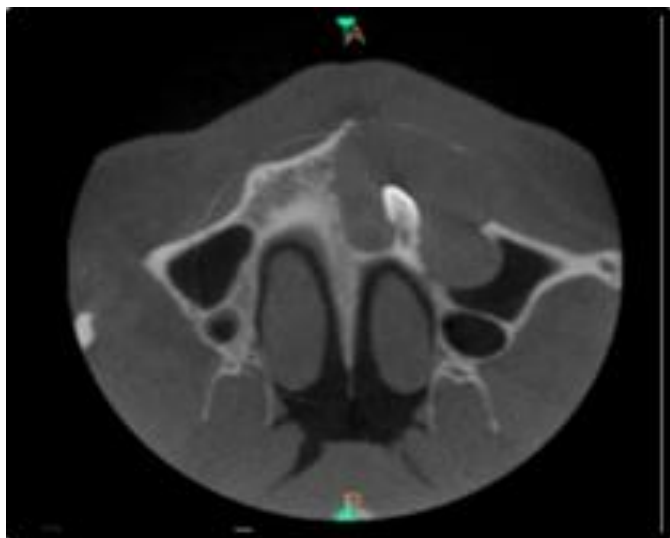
Axial and Sagittal view in cone Beam Computed Tomography to see the extent lesion.
